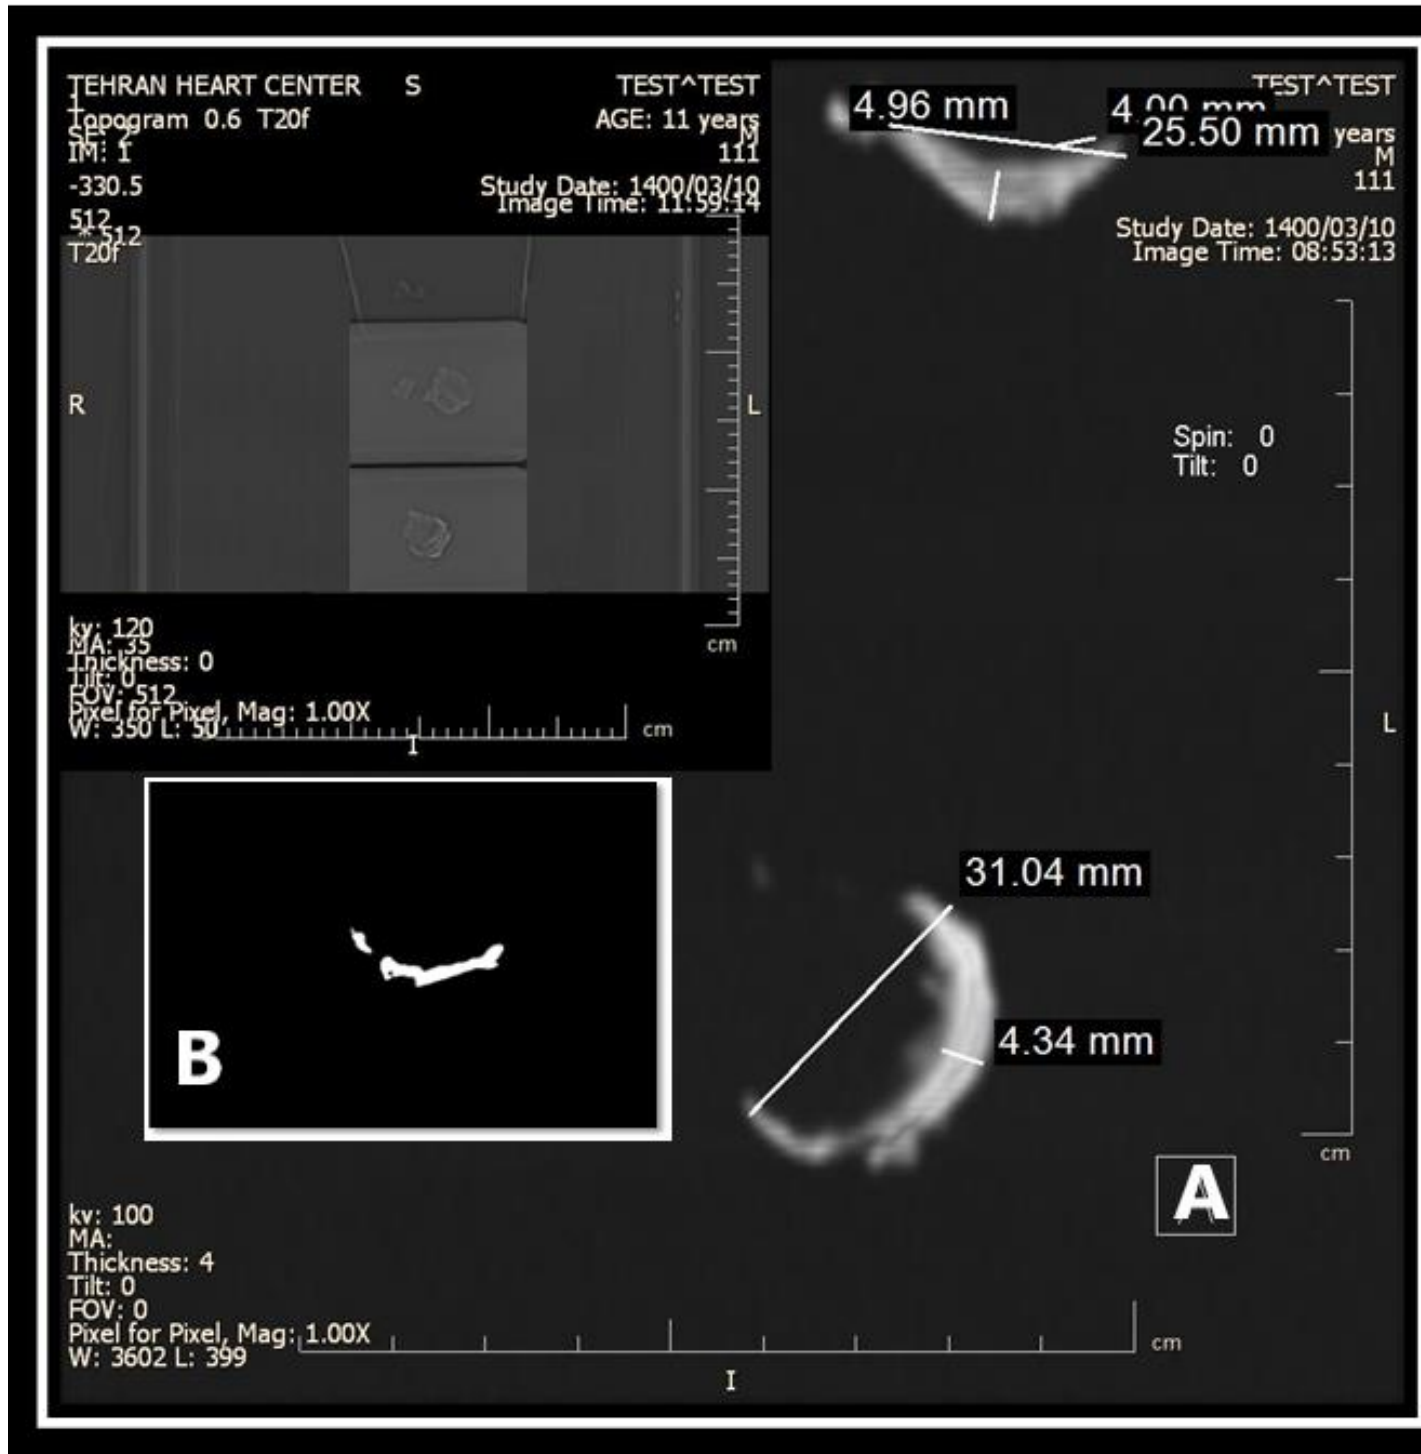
A: Dual energy dual source CT using SOMATOM Definition Flash (Dual-Source) Siemens 2009 shows the presence of laminated layer B: Low-resolution regular 16 slice single source spiral CT shows the calcified cyst wall
